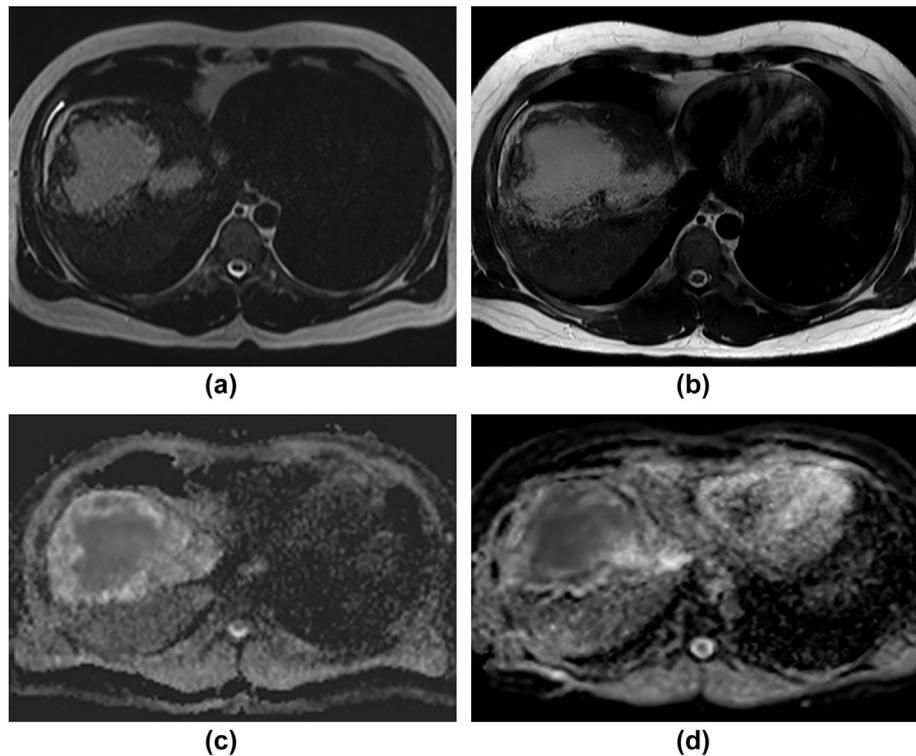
One-year interval MRI follow-up of a large, right-sided type 3 AE lesion, from a patient receiving albendazole therapy. Axial T2-weighted features on the (a) initial and (b) 1-year follow-up scan, allowing for technical and positional differences demonstrate stable appearances both in terms of size and morphology. Contemporaneous ADC maps derived from three b-values (0, 50, and 800 s/mm²) obtained (c) initially and (d) after 1-year, however, demonstrate ADC reductions at the lesion margin, which could yet yield an alternative biomarker for the assessment of treatment response.
